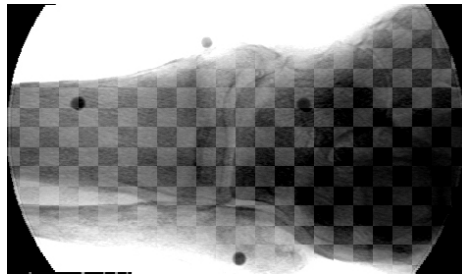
position based servoing; 1: start image; 2: orbital and length change; 3: angulation change; 4:length change 5: target image superimposition; 6: length changed and X-ray superimposition; 7,8: placement of pedicle screw
